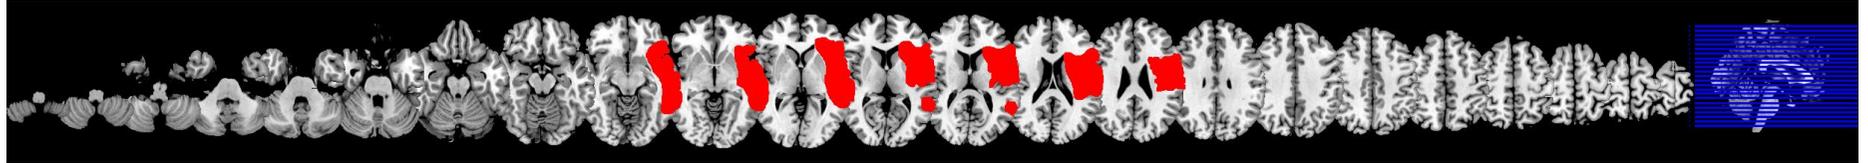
Participant's lesion maps. CT and MRI scans were reviewed by M.O. and T.C (consultant neurologist), who delineated lesion boundaries. Note there is no lesion map for EE as lesions could not be delineated of CT with precision. Lesion regions were then mapped using MRICron (C Rorden et al., 2007b) ch2bet.nii template and multislice views were created using axial slices, $z=14,20,26,32,38,44,50,56,62,68,74,80,86,92,98,104,110,116,122,128,134,140,146$. All lesions have been flipped to the right hemisphere. Sagittal slices for visualization are provided on the far right.
